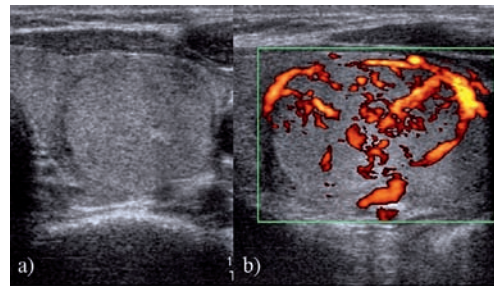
A 46 years old man with papillary carcinoma of the thyroid: a) transverse gray scale US scan shows of a smooth contoured, isoechoic, wider than tall shaped nodule. b) power Doppler US, longitudinal scan, shows marked intranodular vascularity. The maximal diameter of the nodule is measured 18 mm.
